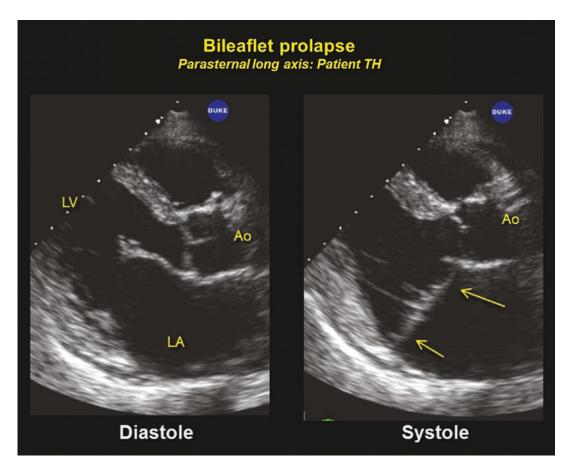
Parasternal long axis two-dimensional echocardiographic still frames showing marked prolapse of the A₂ and P₂ scallops
